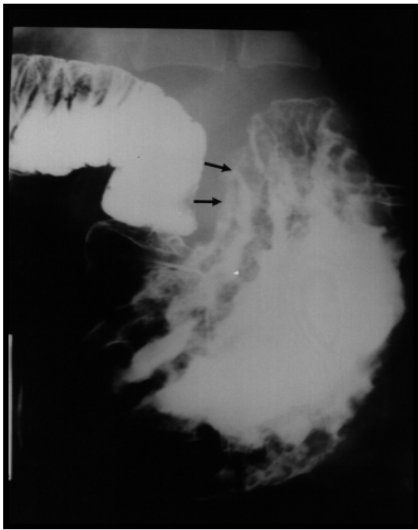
Barium meal radiographic picture showing markedly thickened and irregular gastric mucosal folds (arrows).
